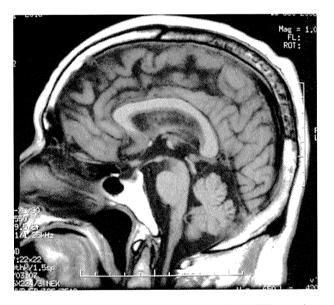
T1-weighted image of patient 9 with R70W mutation shows marked thinning of the medulla and upper cervical spinal cord.
